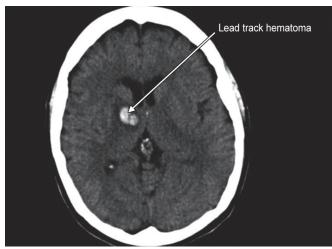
Postoperative CT scan showing small hemorrhage as complication
